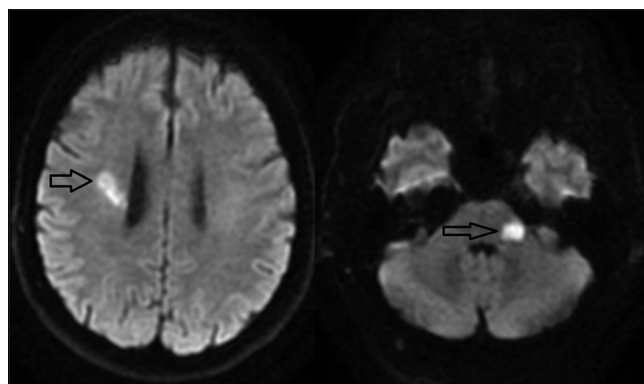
Right corona radiata infarct and left cerebellar peduncle infarct on MRI brain
